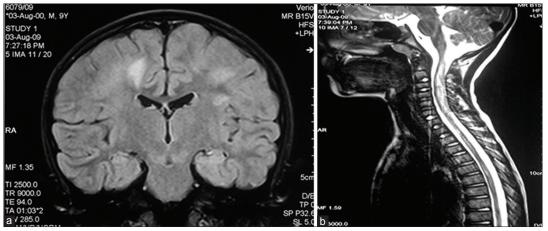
Magnetic resonance imaging (MRI) brain and spine of patient with multiple sclerosis (MS). (a) Fluid-attenuated inversion recovery sequence showing periventricular asymmetrical diffuse hyperintensities. (b) MRI spine T2-weighted sequence showing extensive cervical and thoracic hyperintensities (This patient was diagnosed MS)
